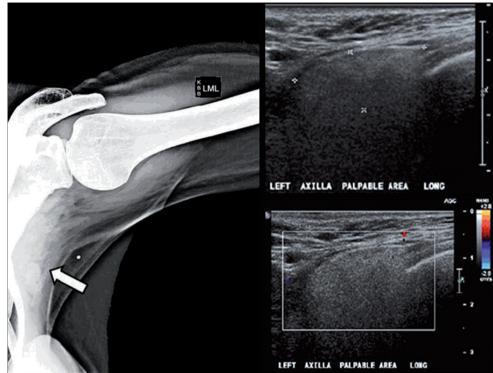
MLO spot compression mammogram of a palpable axillary lump in a 56-year-old woman shows enlarged lymph nodes of varying sizes (*arrow*). She had silicone implants without perceptible changes or other symptoms of leakage. Longitudinal US of the palpable nodes shows well-defined, echogenic, enlarged lymph nodes with a snowstorm appearance and incoherent posterior shadowing and silicone within nodes. There is no flow in the lymph nodes on color Doppler US.
